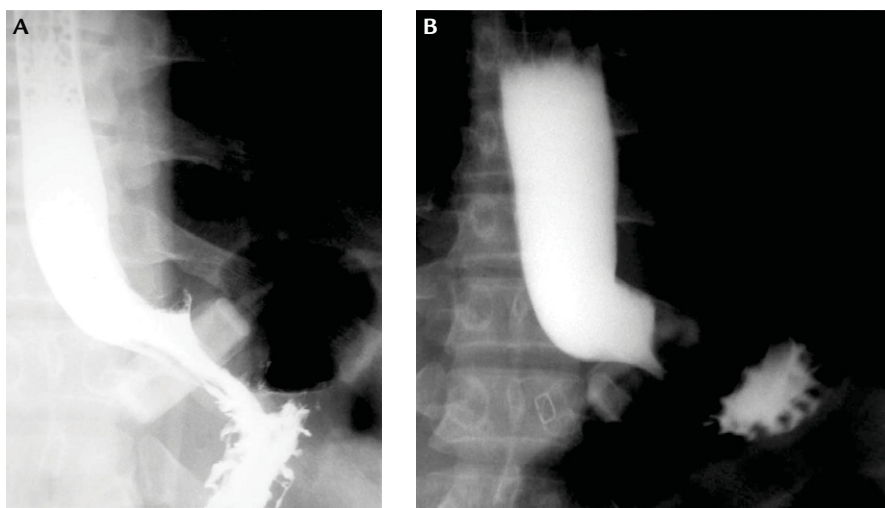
(A) Upper gastrointestinal radiograph after placement of the laparoscopic adjustable gastric band (LAGB) with normal stoma. (B) Upper gastrointestinal radiograph of stoma stenosis after LAGB placement.
